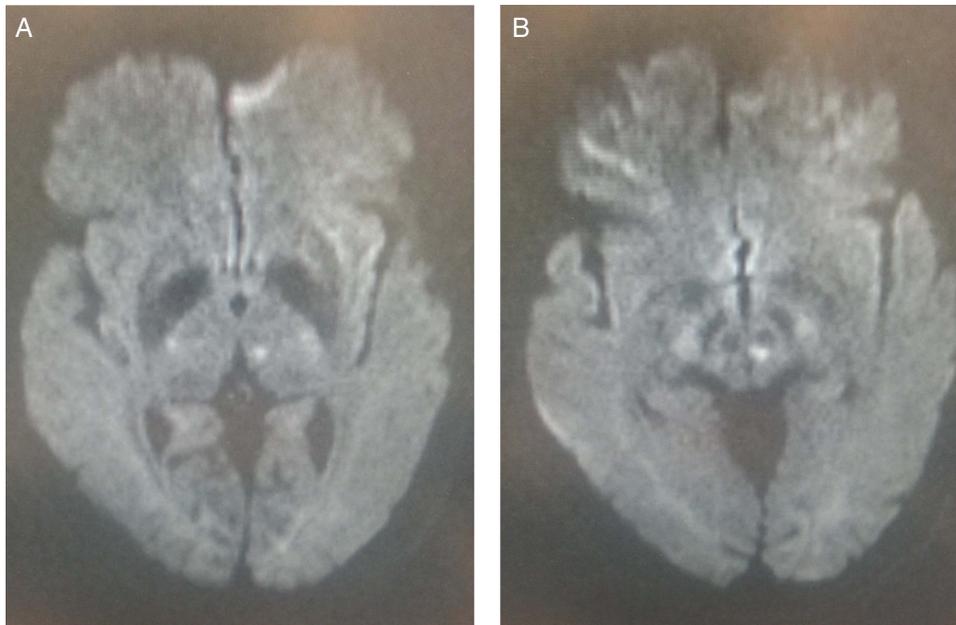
(A) MRI diffusion weighted imaging (DWI) image showed a tiny infarct in the left thalamus. (B) MRI DWI image showed a tiny infarct in the left midbrain.
